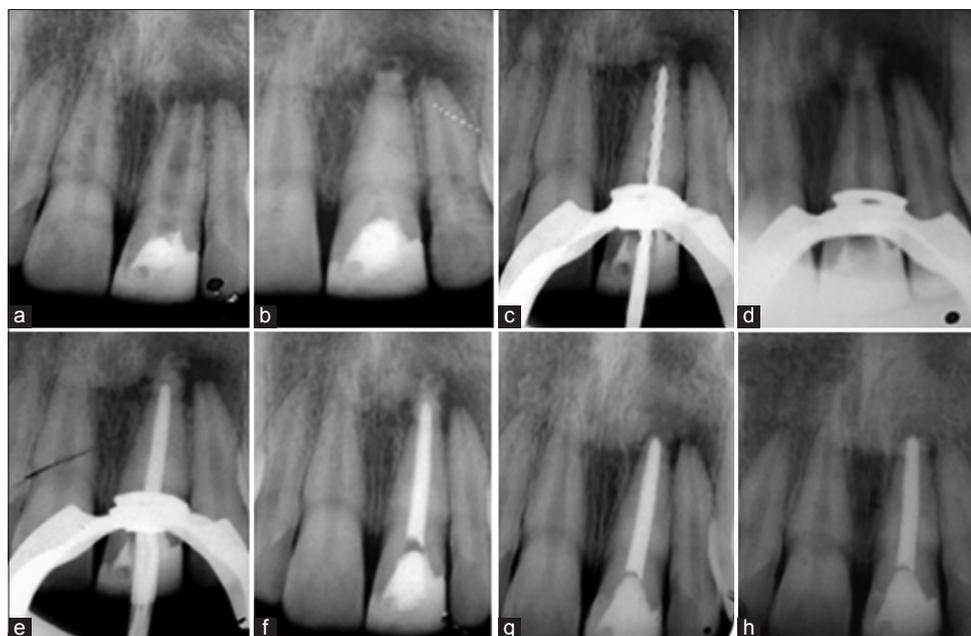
(a) Diagnostic radiography, (b) medication intra-root canal, (c) radiography of the absence of calcium hydroxide, (d) radiography after the creation of the calcium hydroxide plug, (e) cone test radiography, (f) final radiography, (g) radiographic control after 3 months, (h) radiographic control after 1 year.
